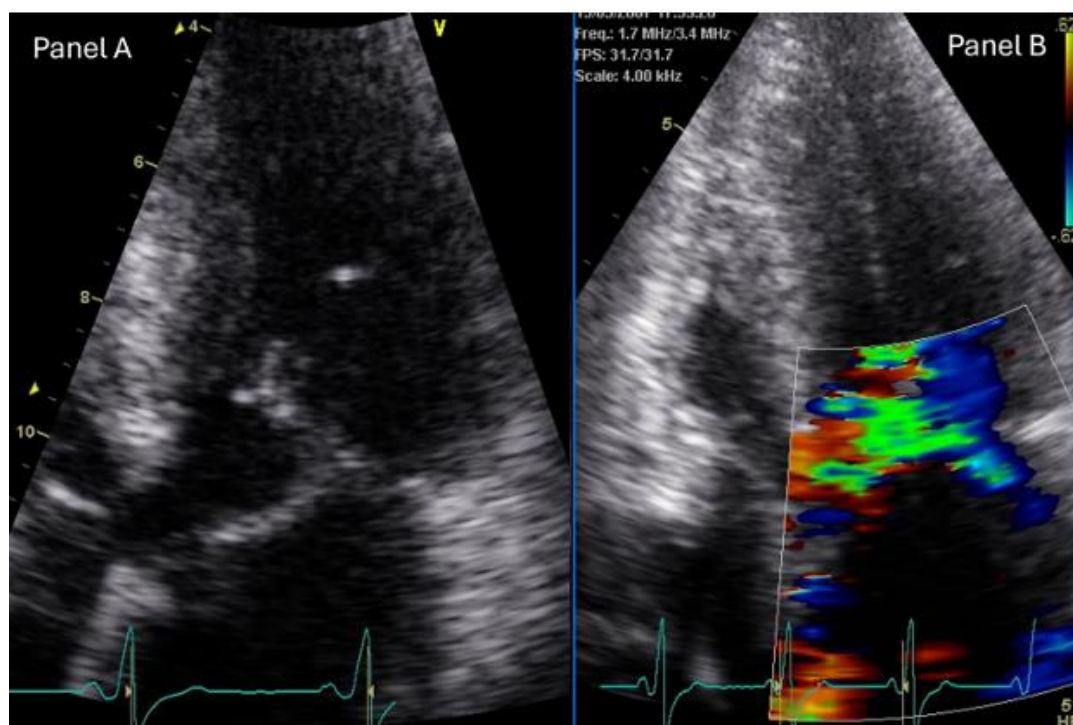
Echocardiogram of a patient with obstructive hypertrophic cardiomyopathy. Panel A: Two-dimensional imaging apical 4 chamber view showing asymmetric predominantly septal left ventricular hypertrophy with systolic anterior motion of the mitral valve leaflets. Panel B: color imaging showing left ventricular outflow tract obstruction at mid systole and posteriorly directed mitral regurgitation.
